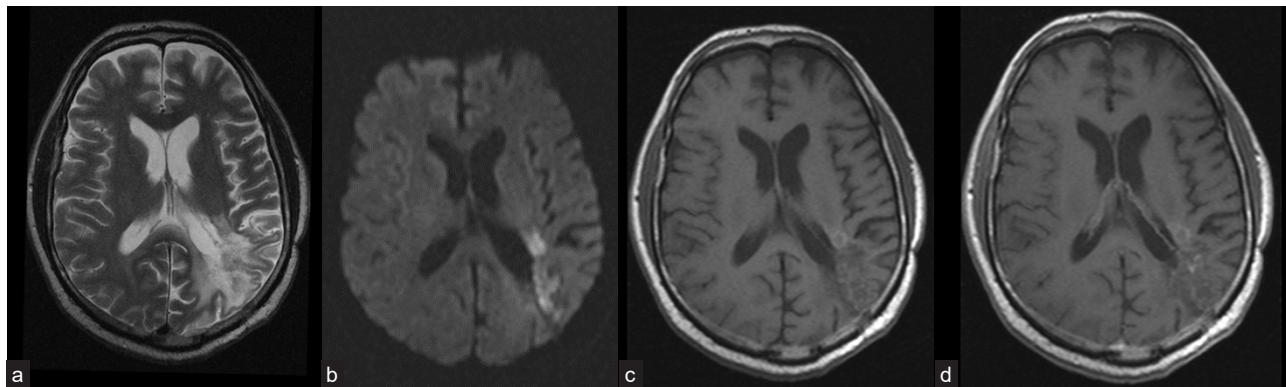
Contrast-enhanced MRI of the brain 6 months after sPDT: (a) T2- reduction of perifocal edema area; (b) DWI (b 1,000) – restriction of diffusion in and to the treatment zone; (c) T1- before contrast – small hyperintense area to the front of the treatment zone; and (d) post-contrast T1 – small area of slight contrast substance accumulation in the treatment zone.
